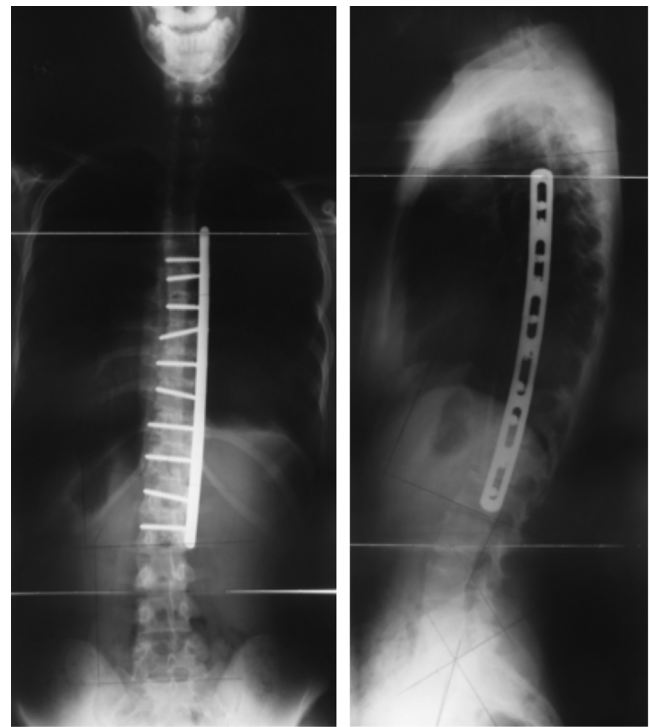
T5-L2 fusion: anteroposterior and lateral radiographs after 1 year.
